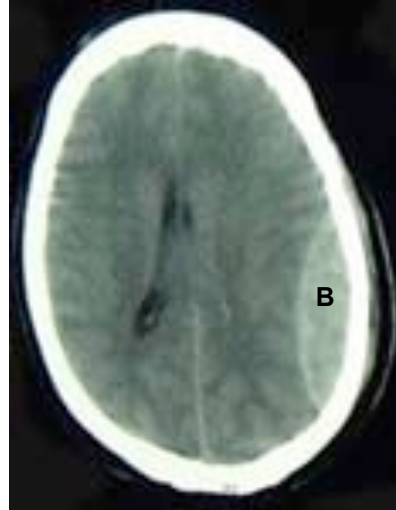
CT scan showing a left occipito-parietal extradural haematoma (B).
